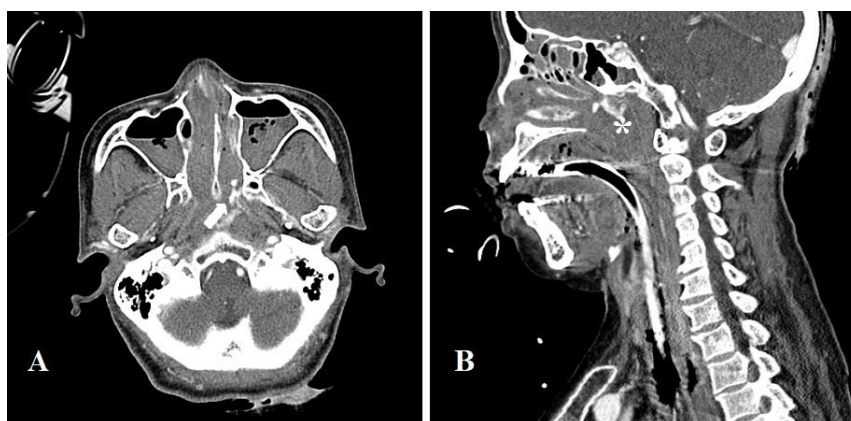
Contrast-enhanced Neck CT (A) Axial image; extravasation of contrast dye from the left posterior nasal cavity (arrow) (B) Extravasation of contrast dye to the left lateral nasopharynx with an inferior extension indicating the possibility of active bleeding.
